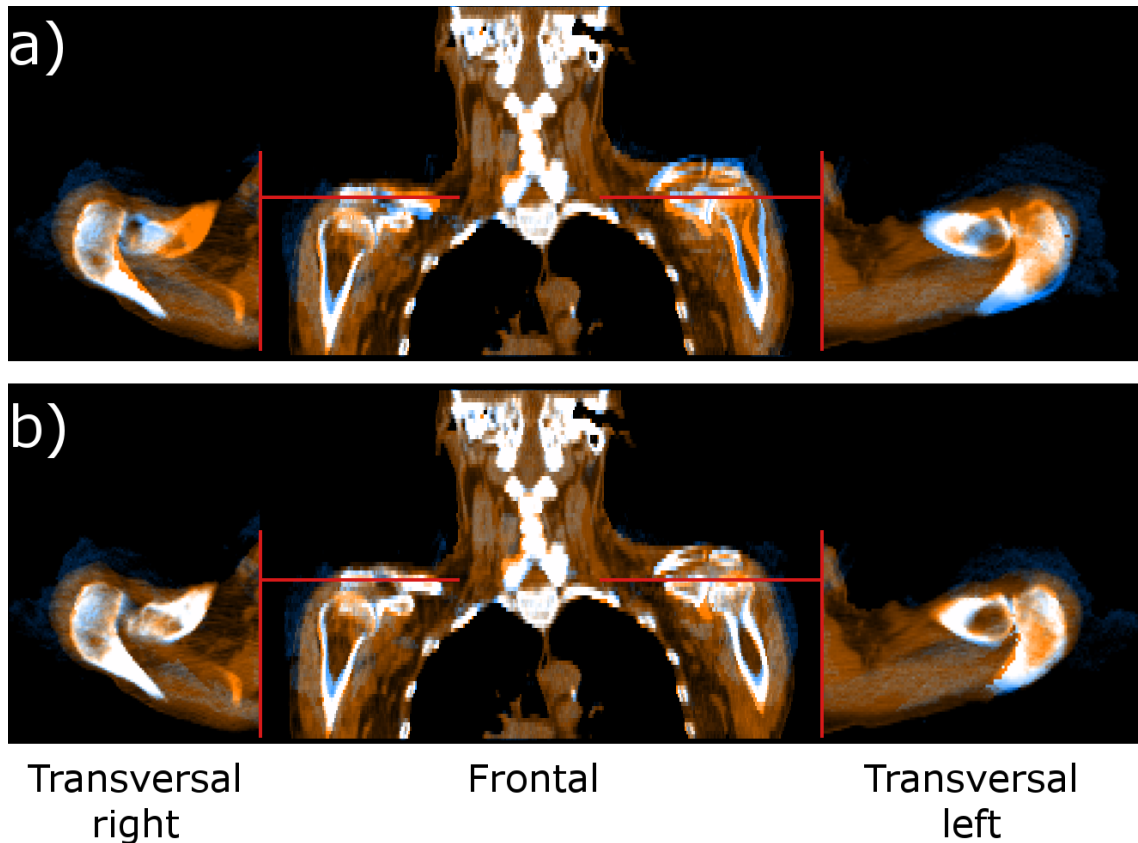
Comparison of the visual registration quality of the automated kinematics-based registration of the large arms-up to the arms-down posture between the use of a) ball-and-socket 3 DoF and b) free 6 DoF acromioclavicular joints during the optimization procedure. As overlay, the original arms-down CT image (orange) and the transformed and re-sampled image as a result of the registration (blue) is shown with a focus on the bony anatomy and a spatial focus on the acromioclavicular joints. The red lines indicate the locations of the image slices taken for both transversal views in the panels on the left and right. The panel in the middle shows an exemplary frontal slice.
